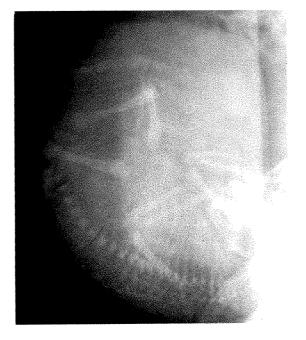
The length of the fetal lumbar spine can easily be measured in such a roentgenogram and the value obtained used as an aid in the prediction of fetal length according to the method of Fagerberg and Ronema.² Also observe the placenta implanted in the fundus posteriorly (the mother is facing the observer's left).
